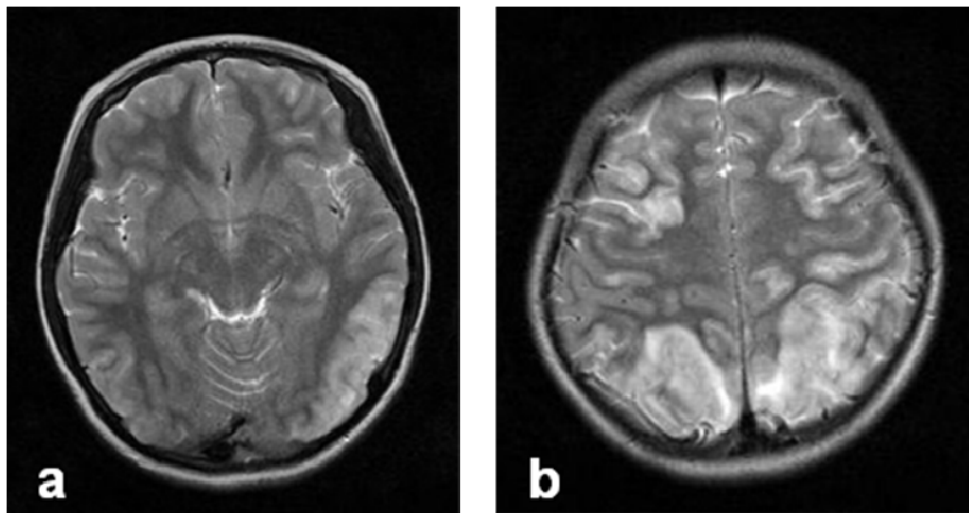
Magnetic resonance images (MRI) of the brain (T2-weighted image) showing increased intensity in the cortex and subcortical white matter of left occipital (a), bilateral parietal and right frontal lobes (b), consistent with PRES.
